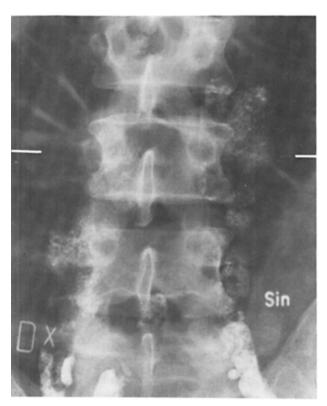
b. Lymphography. Several slightly enlarged lymph nodes with a pathologic structural pattern are seen at the level of LIII-IV. The level of the CT scan is indicated.
